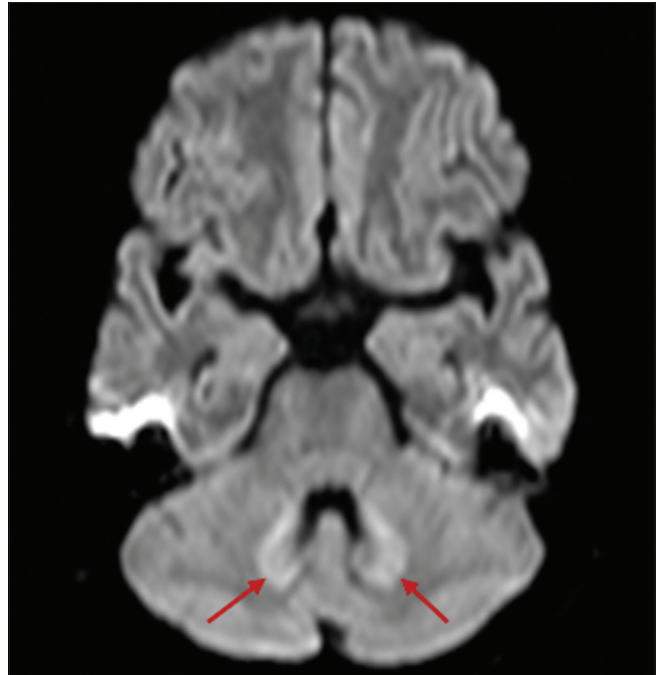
Axial DWI shows the bilateral symmetrical hyperintense signal in dentate nuclei of cerebellum
